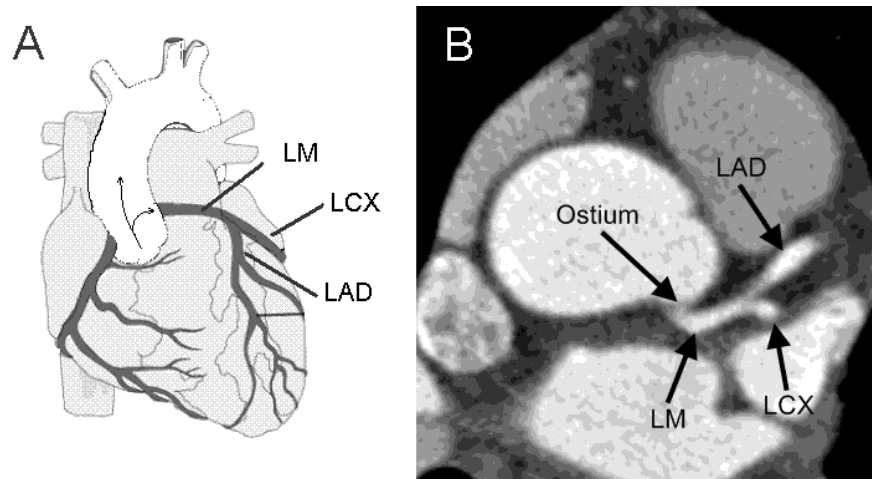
Panel A shows LCA anatomy, note that inflow in the ostium deviates from aortic flow. Panel B is an example of one CT slice image used for the LCA reconstruction. These images permit to distinguish the coronary ostium, the left main artery (LM), the left anterior descending (LAD) and left circumflex (LCX) branches.
